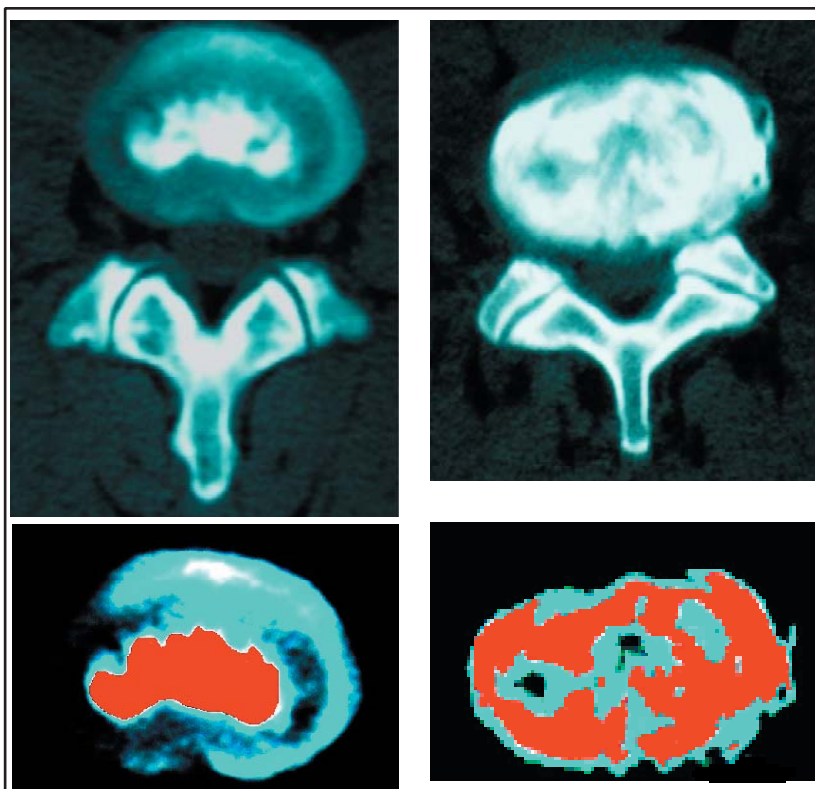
Post discogram axial CT images of a normal disc (top left) and abnormal disc (top right)- Below are the same discs with computer contrast and color enhancement added to reveal separation of nuclear (red/dark gray) and annular (blue-green/light gray) regions.
